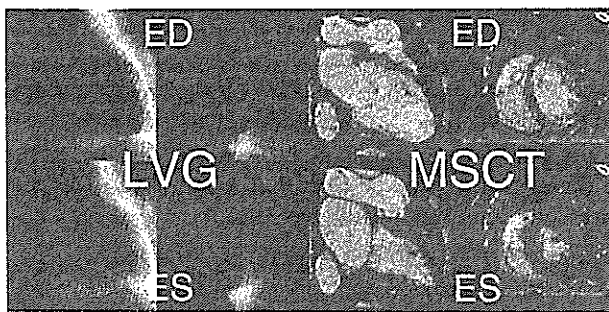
A 69-year-old woman with angina pectoris (patient 7). Left ventriculography (LVG) and multi-slice computed tomography (MSCT) (image quality excellent) showed mild hypokinesia in left anterior descending coronary artery (LAD) territory (a). LV wall motion scores (b) between MSCT (inside panels) and LVG (outside panels) agreed in all segments. ED, end-diastole; ES, end-systole
